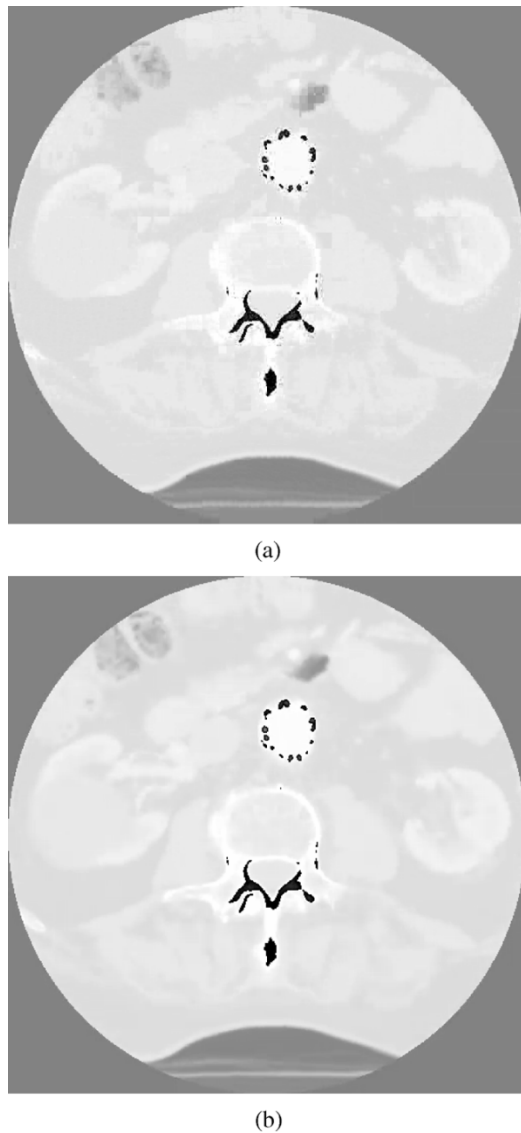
The reconstructed images of the 44th frame of sequence "CT" at bit rate of 438.19 kbps. (a) MPEG-4. (b) H.264.
